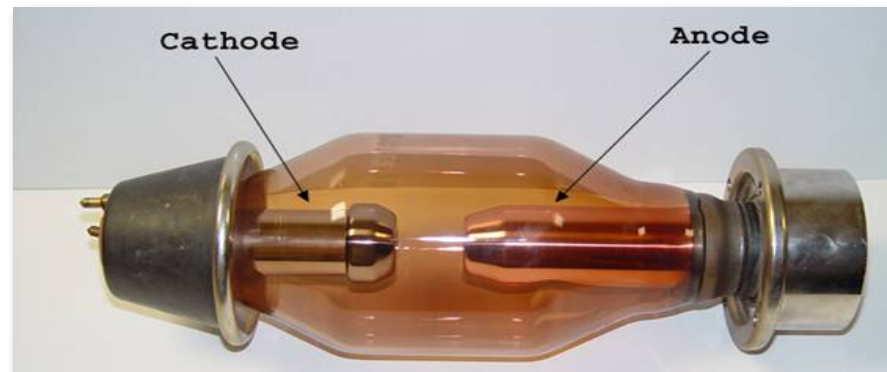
Structure of a typical x-ray tube, including the major operational parts.
